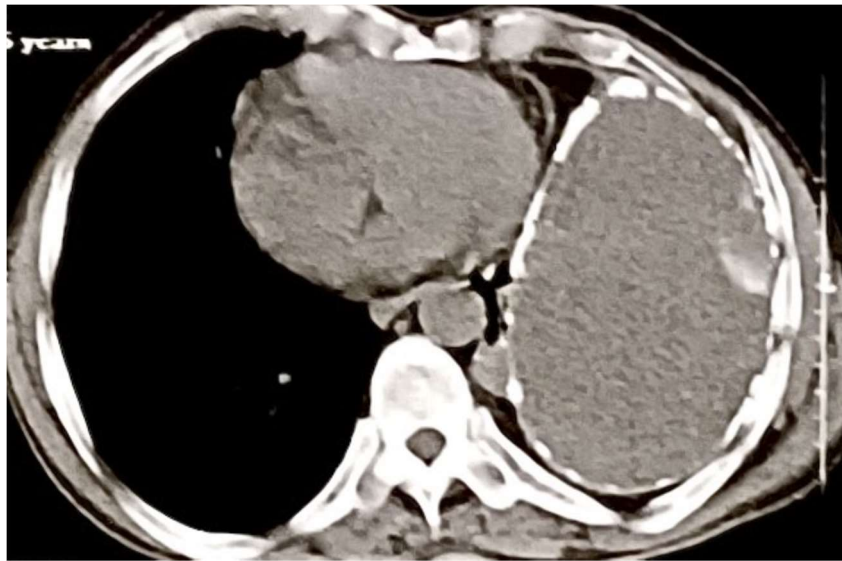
Mediastinal window of High-resolution Computed Tomography (HRCT) Thorax showing a large encapsulated pulmonary Hydatid Cyst
